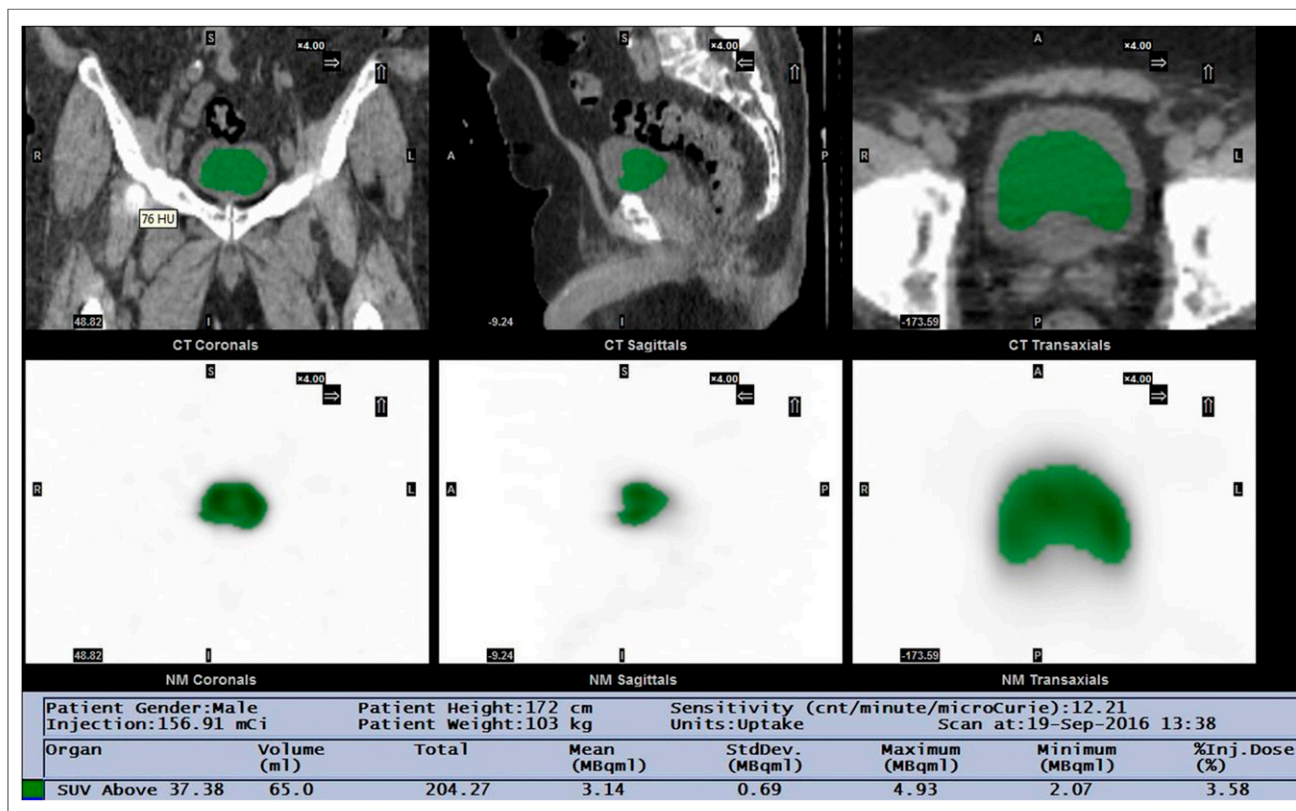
In vivo (SPECT) measurements. Example screenshot is shown of clinical quantitative software utility for method B. CT images (top) confirm that VOI selected (green) on SPECT images (bottom) falls within urinary bladder. Absolute quantitative measurements are shown in text at bottom.
